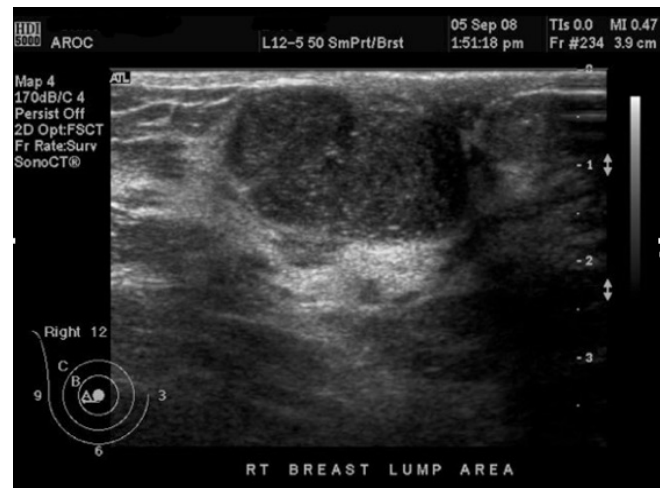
Ultrasound examination demonstrating a 3.1 x 1.7 x 2.5 cm fairly well-circumscribed solid mass at 7 o'clock.
